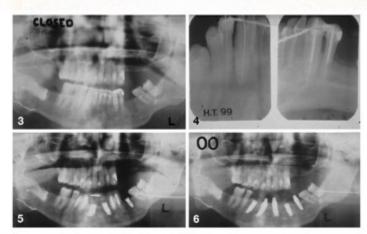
Panoramic radiograph of malaligned and periodontally compromised lower teeth.
